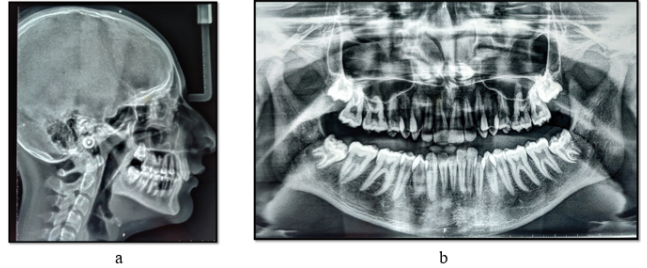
a) Lateral Cephalogram, b) Orthopantomogram
